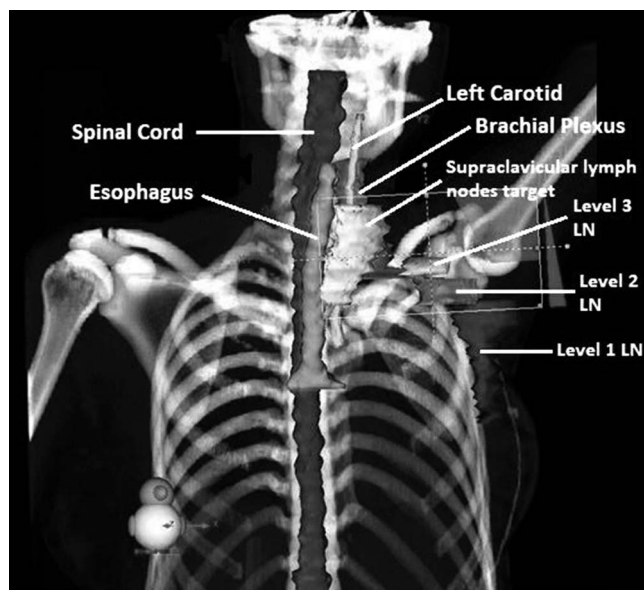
CT image showing planning target volume, organs at risk, and contouring view in three dimensions in a patient with left-breast cancer. LN: lymph node.
